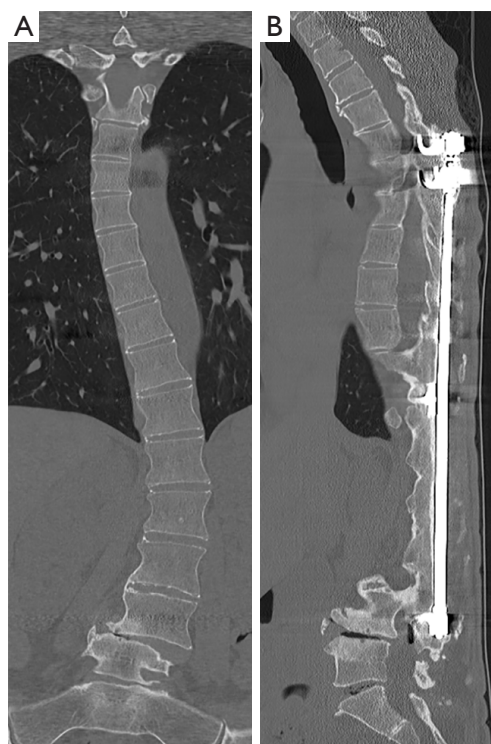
Preoperative computed tomography of the thoracic and lumbar spine. (A) Coronal and (B) sagittal computed tomography scans (in the bone window range of densities) obtained prior to the operation, demonstrating chronic scoliotic curvature, severe degenerative changes, and placement of the preexisting Harrington rod.
